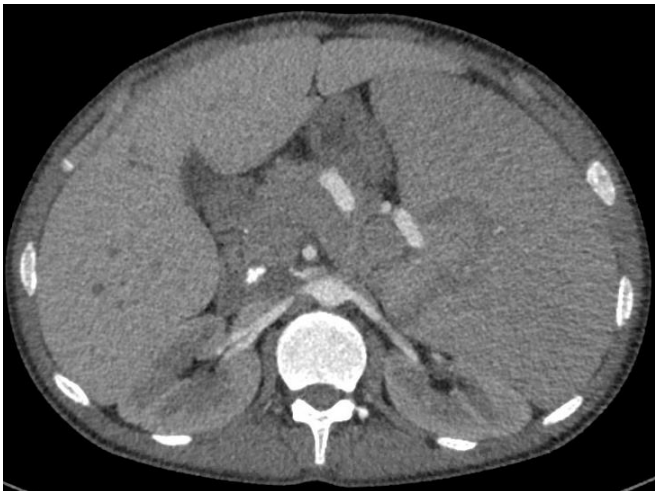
2 CT-scan image that was obtained 3 months before above presentation which shows normal left kidney morphology with patent left renal artery.
